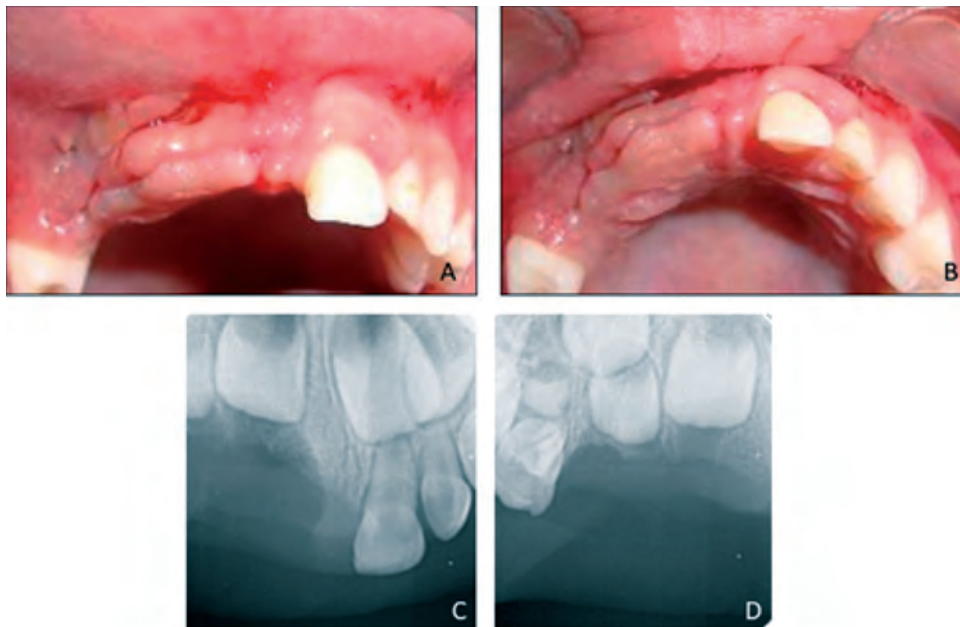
(A and B) Intraoral appearance after 15 days in an occlusal view: adequate maxillary arch contour and absence of teeth 51, 52 and 53 extracted in surgery, (C and D) Periapical radiographs after 15 days: compatible radiolucent area with the remaining cavity of the lesion. Germs of teeth 11,12 and 13 preserved.
